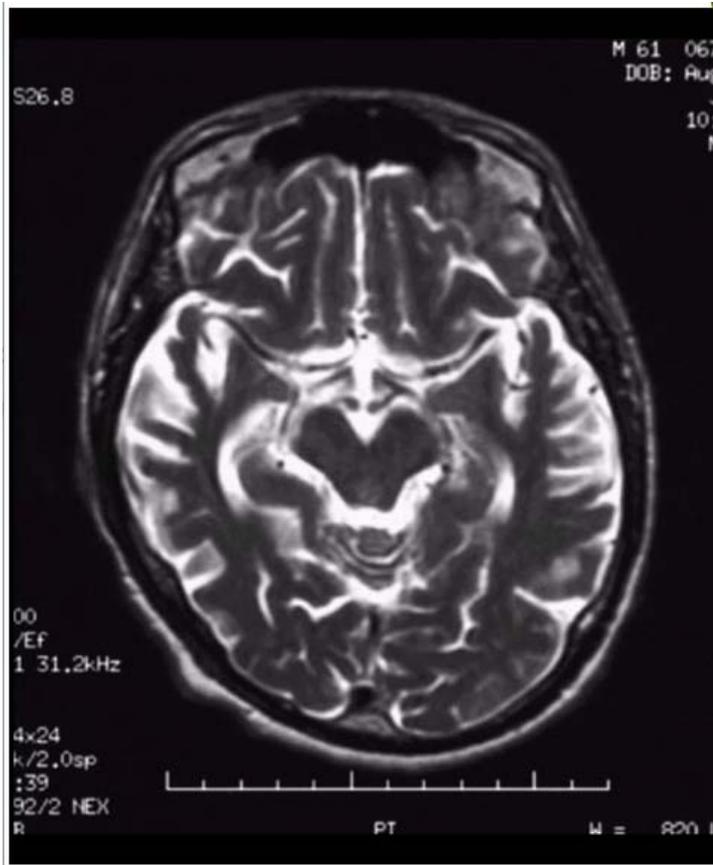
Axial, T2-weighted MRI scan of the patient's brain. Shows atrophy in the temporal lobes.
